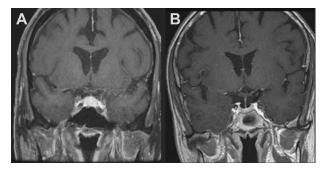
(A) T1-weighted MRI of the brain demonstrating enlarged and enhancing pituitary body and stalk after gadolinium administration in a patient who developed hypophysitis after ipilimumab alone. (B) T1-weighted MRI of the brain demonstrating normal-appearing pituitary gland in a patient who developed hypophysitis after pembrolizumab alone.
